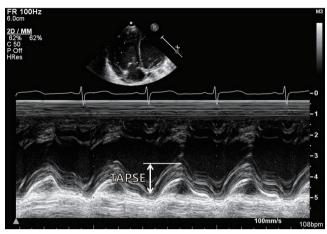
Measurements of the tricuspid annular plane systolic excursion (TAPSE) using M-mode echocardiography at the junction of the tricuspid valve plane with the free wall of the right ventricle.
